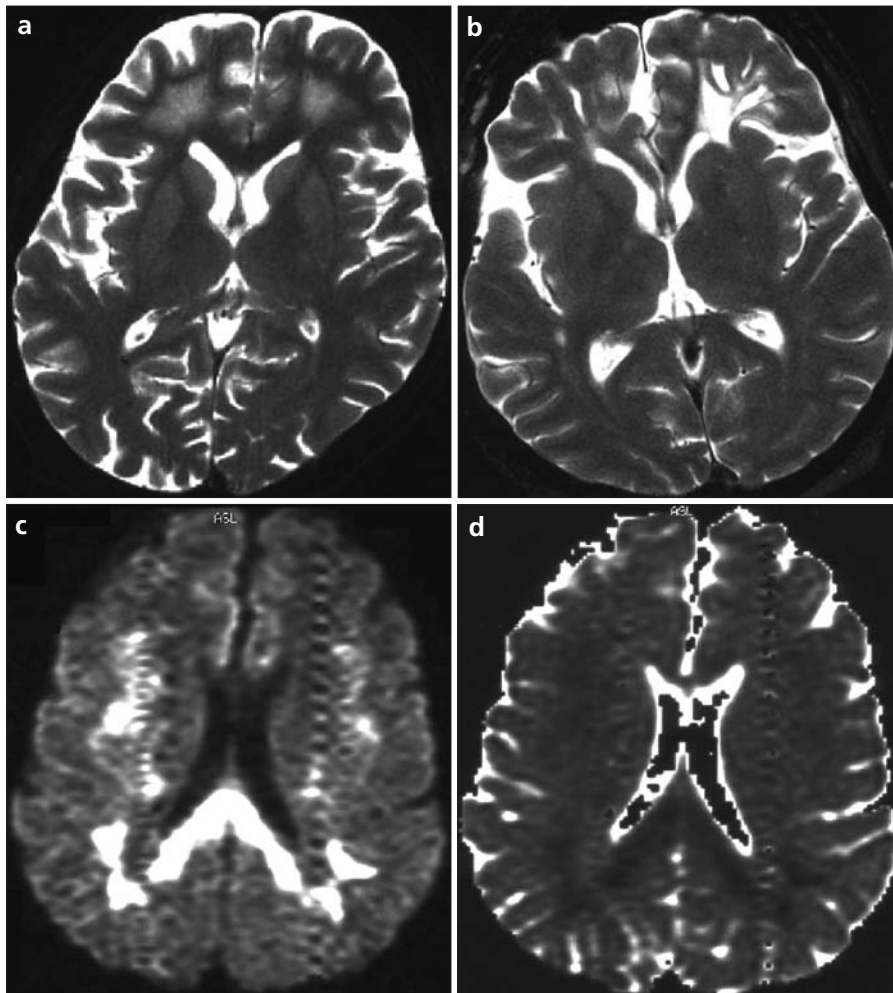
a-d. Transverse T2-weighted MR image (a) shows the early leukomalacic changes detected in the periventricular white matter in the frontal lobe of a patient with non-Hodgkin lymphoma treated with intrathecal methotrexate. Note the homogenous high signal sparing the subcortical U-fibers. In the late phase, prominent white matter loss accompanied by cystic encephalomalacia is seen on the transverse T2-weighted MR image (b) of a different patient treated with paclitaxel-topotecan due to ovarian cancer. Restricted diffusion on diffusion-weighted MR image (c) and ADC map (d), involving not only the periventricular white matter, but also the corpus callosum in a patient diagnosed with colon cancer and treated with 5-fluorouracil is demonstrated.
